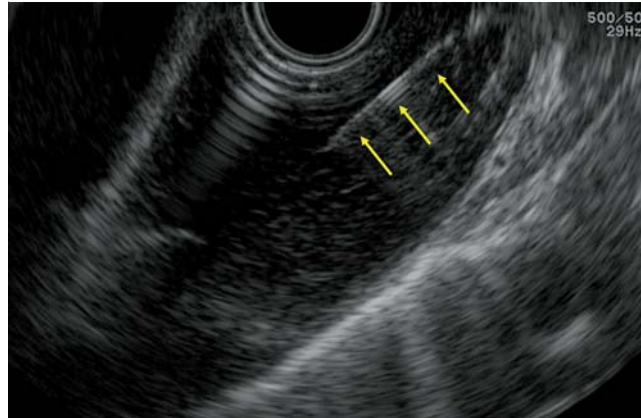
Endoscopic ultrasound showing a hypoechoic thickening in the third layer. Endoscopic ultrasound-guided fine-needle aspiration was carried out using a 22-G needle (arrows).
